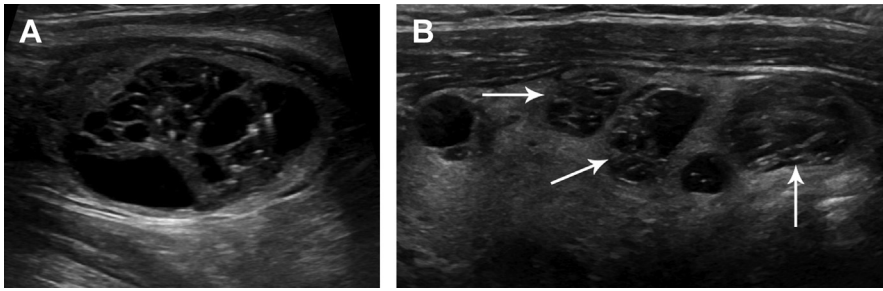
Spongiform nodules. (A) 66-year-old woman with a multinodular goiter. Longitudinal gray-scale image shows a spongiform nodule characterized by multiple small cystic spaces. Spongiform architecture is strongly associated with benign cytology. (B) A 66-year-old man with metastatic papillary thyroid cancer (not shown) also has multiple spongiform nodules (*arrows*) in the right thyroid on longitudinal gray-scale ultrasound. Note the nodules contain PEF indicating the backwalls of small simple cysts.
